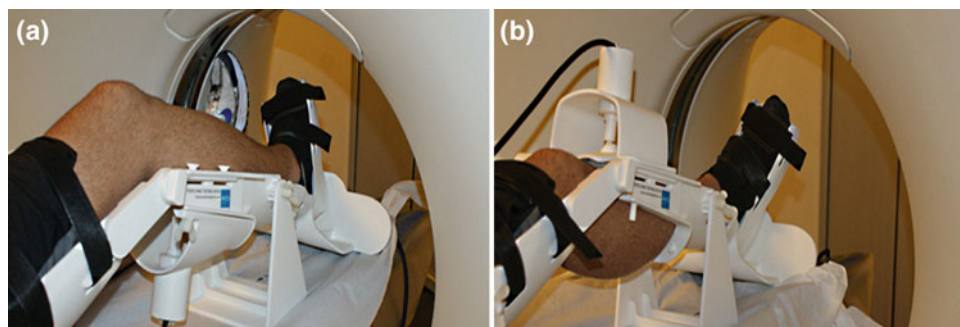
Clinical photograph of the MRI-compatible Porto Knee Testing Device—PKTD[®]. a Patient positioning within the device. b The PKTD actively exerting force upon the tibia using the inflatable cuff. Images courtesy of Rogério Pereira, PKTD[®]
